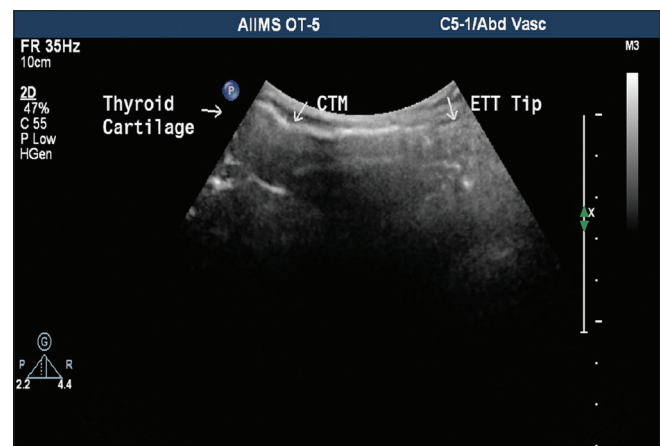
Midline long-axis ultrasonogram of the lower airway (extrathoracic) depicting the cricothyroid membrane (vertical arrow)
